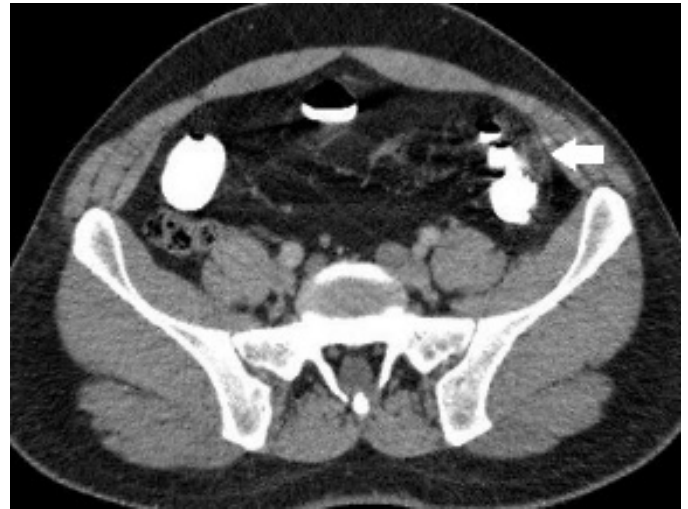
The Axial CT View of Descending Colon Appendagitis
